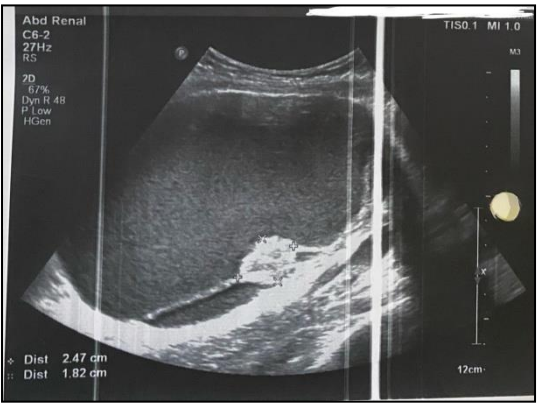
Ultrasound image of the mass showing the solid component within it.
